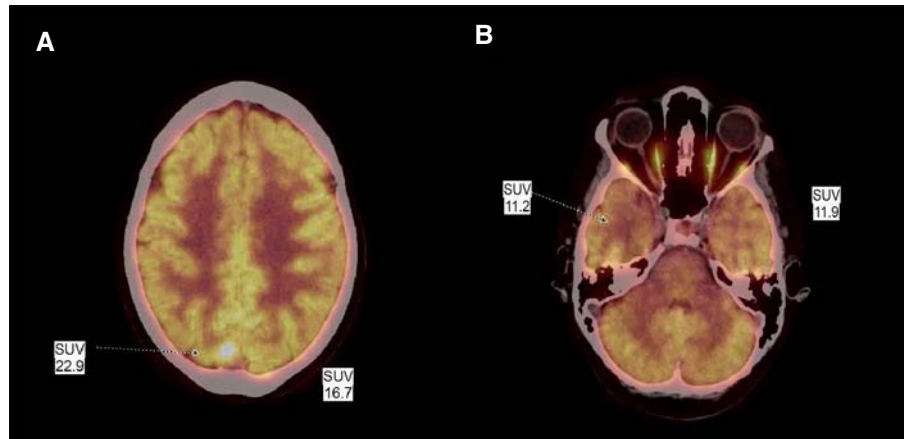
(A) Axial PET scan showing focal increased activity in the right parasagittal occipital lobe with maximum standardized uptake values (SUV) of 22.9 in the occipital lesion, compared to the contralateral side with SUV of 16.7. (B) Axial PET scan of bilateral temporal lobes showing slightly hypo-metabolic region in the right temporal lobe medially with SUV of 11.2, compared for the left side with SUV of 11.9.
